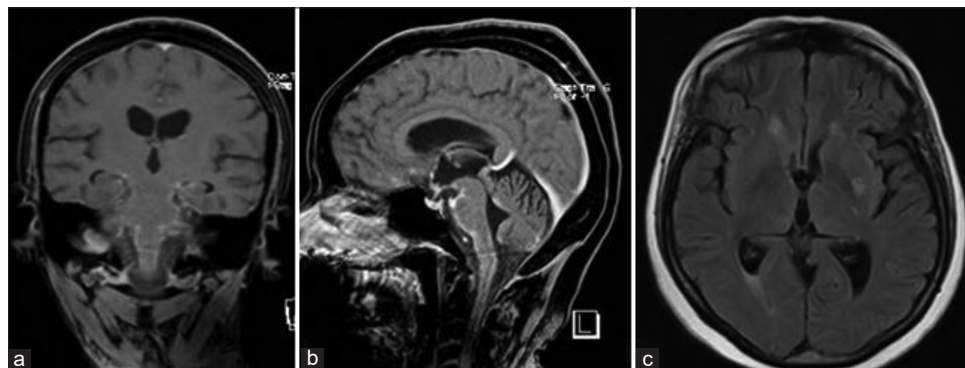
Preoperative magnetic resonance imaging. (a) Coronal gadolinium-enhanced image, (b) sagittal gadolinium-enhanced image, (c) axial T2/FLAIR-weighted image showing a slight reduction in the thickness of the leptomenigeal impregnation of the lateral fissures and frontotemporal operculum on both sides suggestive of diffuse pachymeningitis.
